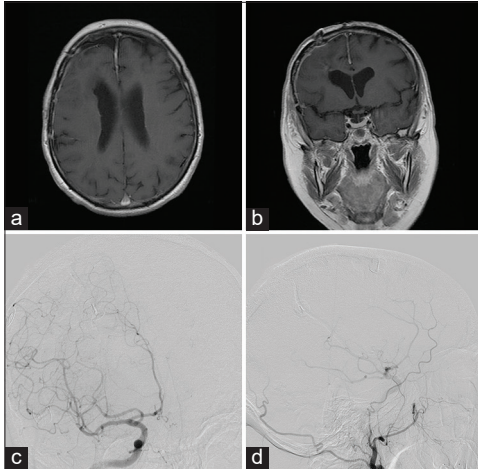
Postoperatively, the patient improved neurologically. Postcontrast magnetic resonance imaging showed complete resection of the meningioma (a and b) and DSA complete obliteration of the dural arteriovenous fistula (c and d).
